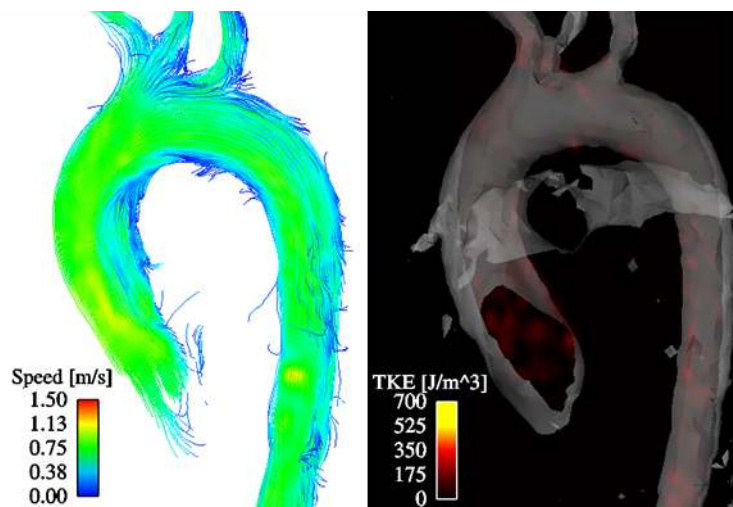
Aortic blood flow at peak systole in a healthy volunteer visualized by 3D streamlines (a) and a TKE map combined with a semi-transparent iso-surface rendering computed from the PC-MRI data (b).
